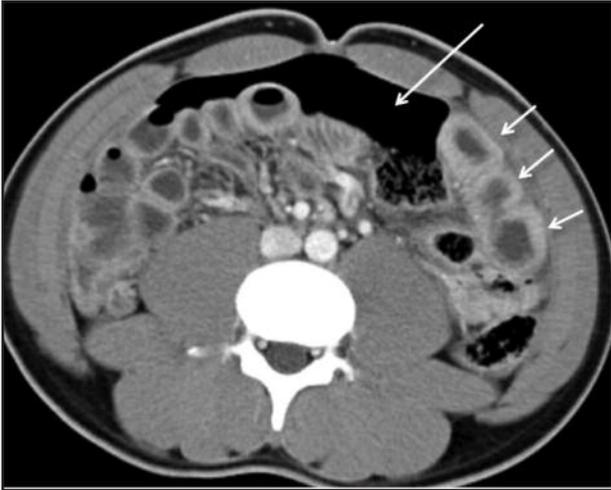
Axial CT abdomen demonstrating bowel wall thickening in a patient with small bowel injury. An 18-year-old man, whose motorcycle skidded. The small bowels are dilated and the walls are thickened (short arrows). Note the massive pneumoperitoneum (long arrow).
